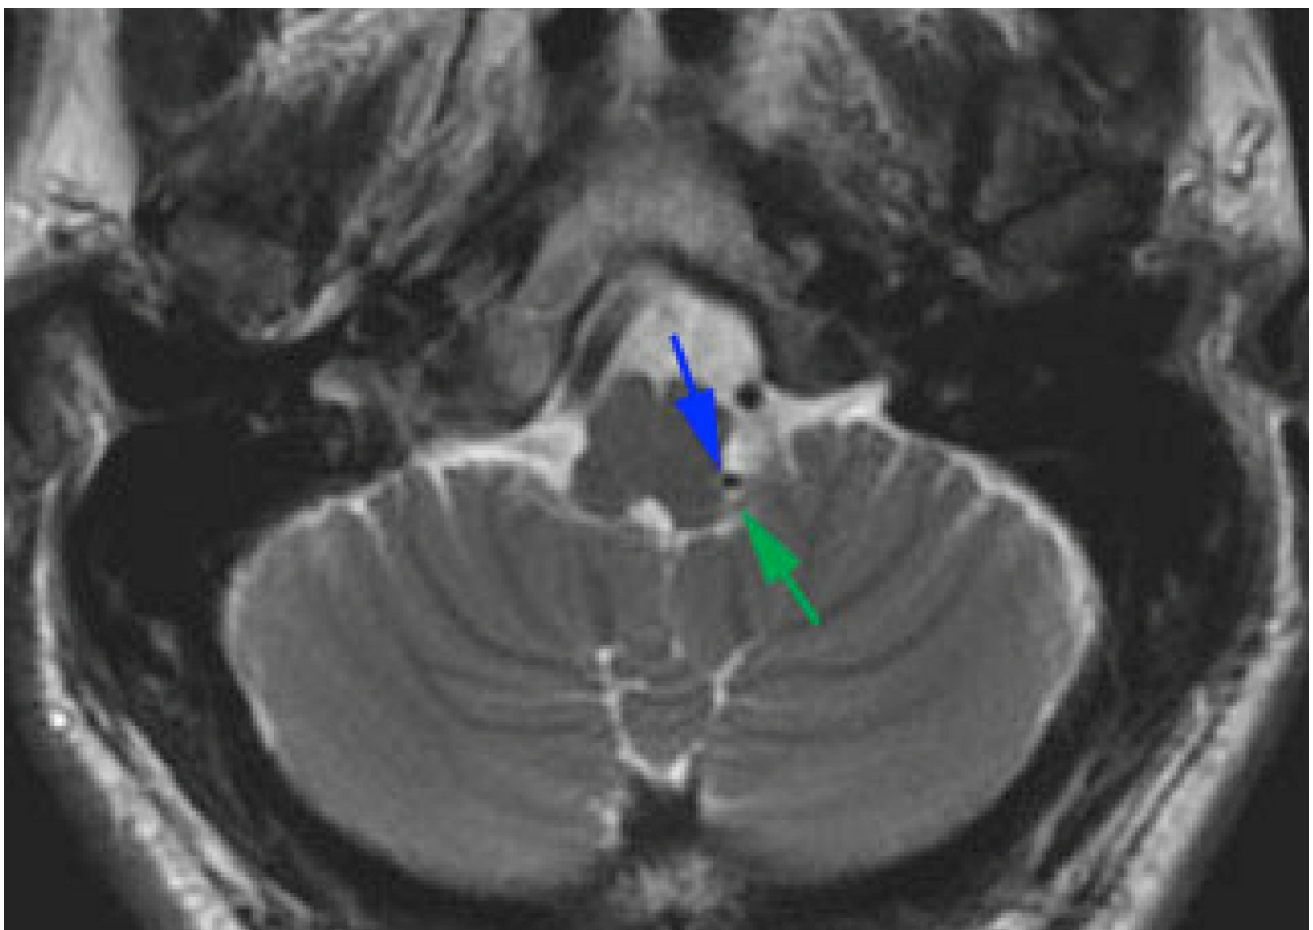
Axial high-resolution MRI demonstrates a vascular loop (blue arrow) at the level of lower cranial nerves near the brainstem (green arrow).
